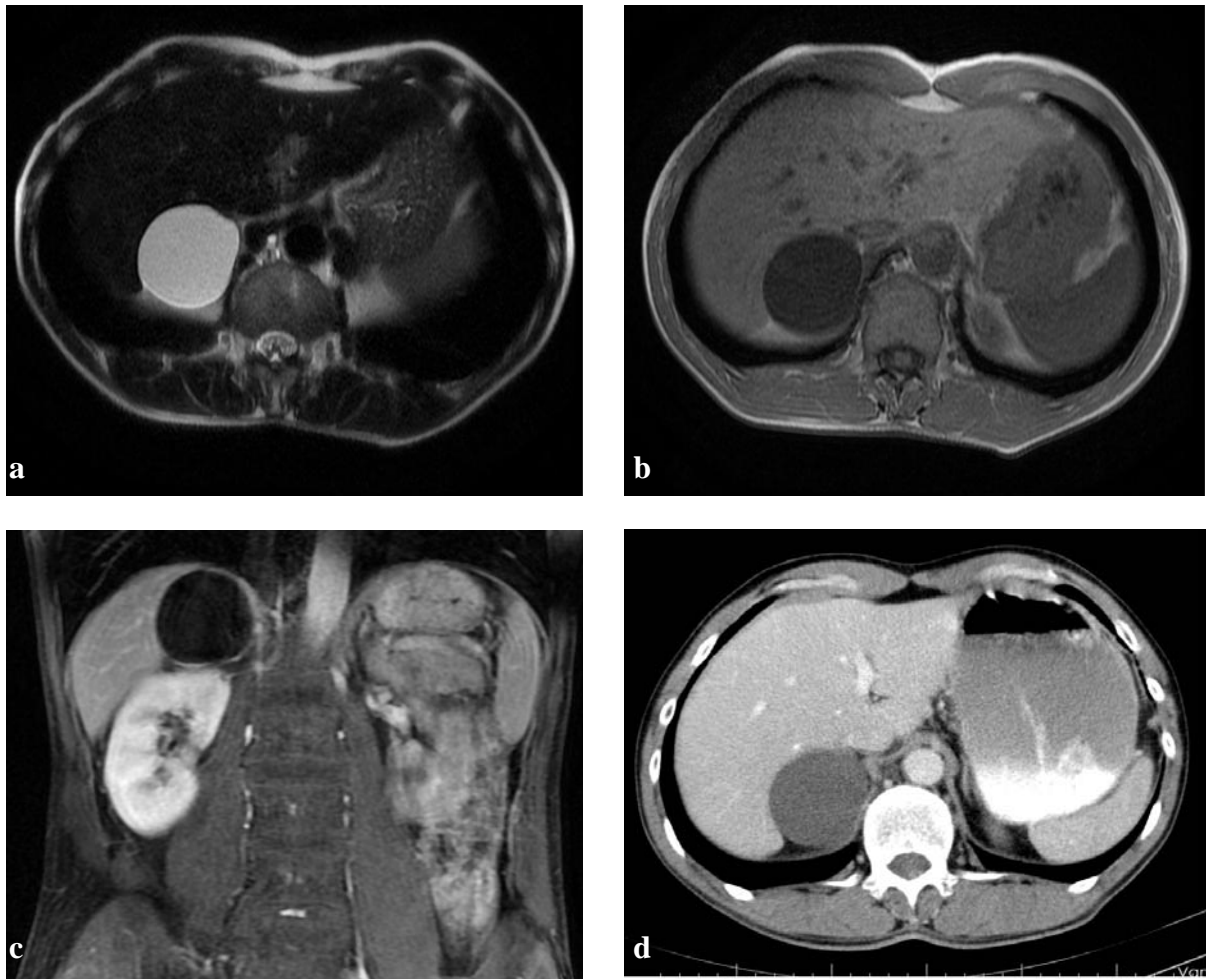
CT (a), T1 (b), T2 (c) and postcontrast T1 (d) weighted MR image reveal the unilocular, wellcircumscribed, pure liquid nature of a right adrenal gland cyst.
